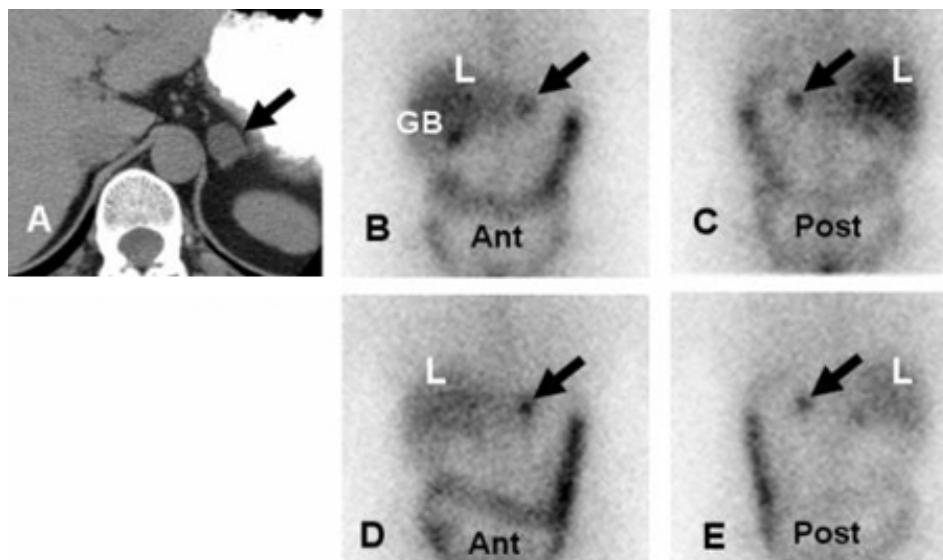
Left adrenal aldosteroma depicted with dexamethasone suppression NP-59 imaging: 57-year-old woman with biochemical evidence of hyperaldosteronism and a left adrenal mass. Abdominal CT (A) demonstrates a 2 cm left adrenal mass (black arrow), anterior and posterior abdominal NP-59 scans (B and C) on the third day post-injection; anterior and posterior abdominal NP-59 scans (D and E) on the fifth day post-injection; abnormal left adrenal uptake (black arrows) occurs early, before day 5 post-injection (B and C); normal uptake in liver (L), bowel (B), and gallbladder (GB).
